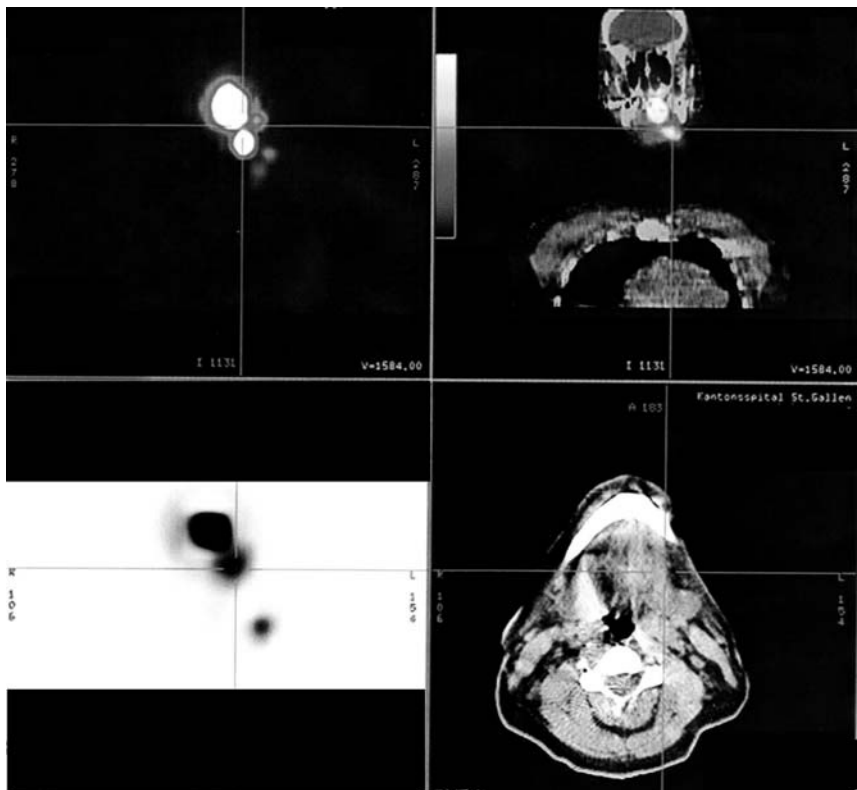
SPECT-CT imaging in OSCC: the image shows a SN at NL I.
